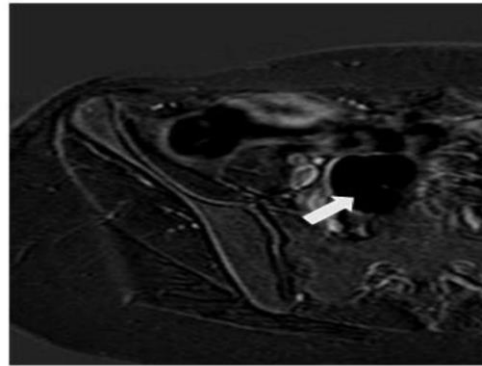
3 30-year female with pelvic pain. Pre and post contrast enhanced T1W MRI images (A and B) of pelvis shows a large adnexal lesion exhibiting hyperintense signal in both pre and post contrast images. Assessment of enhancement cannot be done with confidence. Subtraction image (C) show definite areas of nodular enhancement (arrow) along the periphery of lesion while rest of the lesion shows complete signal void (arrowhead), suggesting the possibility of malignant etiology.
